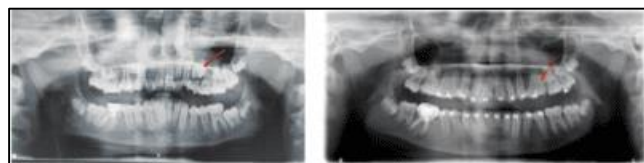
Comparison of pre-treatment and post-treatment OPG radiograph showing position of premolar (red arrow)
